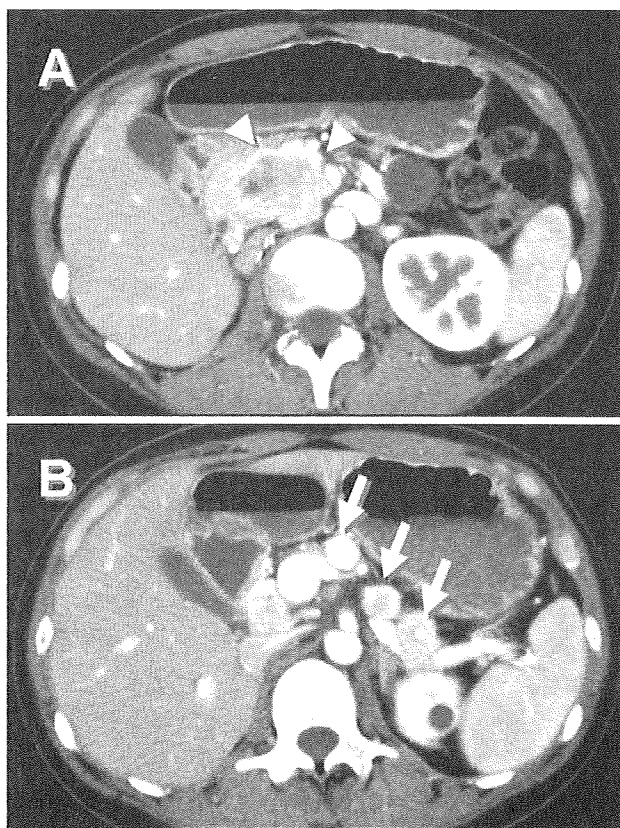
Contrast-enhanced abdominal computed tomography. a The mass in the pancreatic head is heterogeneously enhanced and appears to invade the portal vein (arrowheads). b Multiple pancreatic masses are shown in the pancreatic body and tail (arrows) and are heterogeneously enhanced
